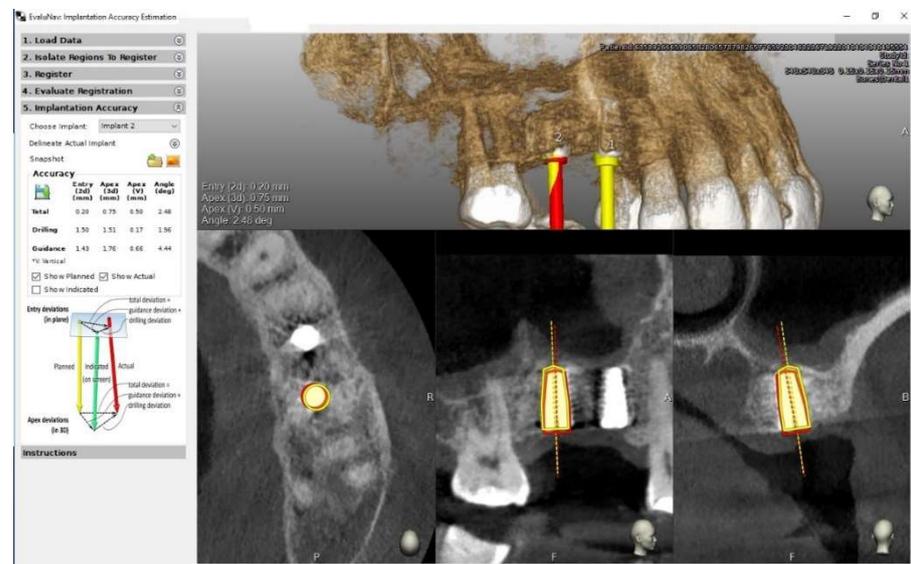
Comparison between planning (yellow) and actual implant position (red) based on preoperative and post-operative CBCT scans.
